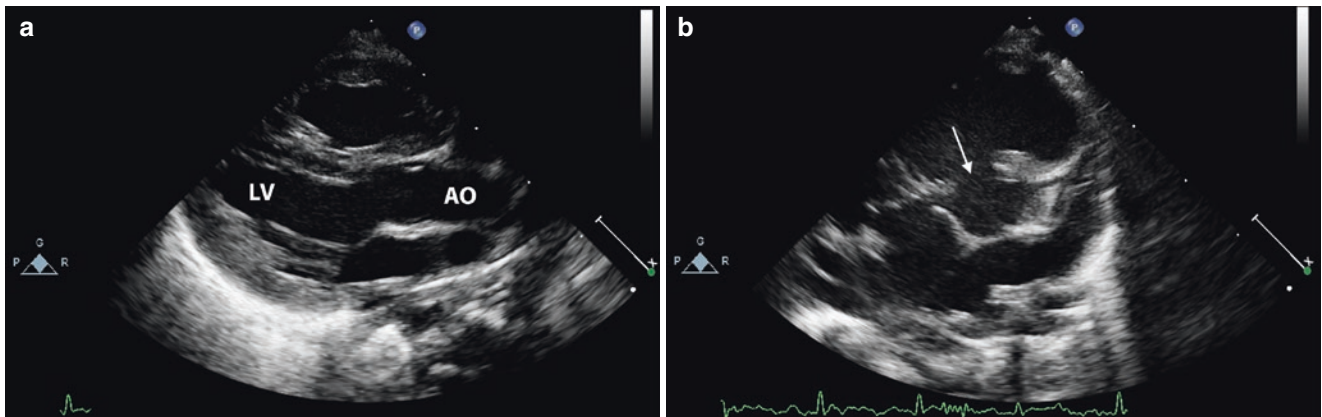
Parasternal long-axis view failing to visualize a large VSD, since the plane of examination is too far to the left (*a*). The defect is obvious (*arrow*) in the parasternal short-axis view (*b*). LV left ventricle, AO aorta
